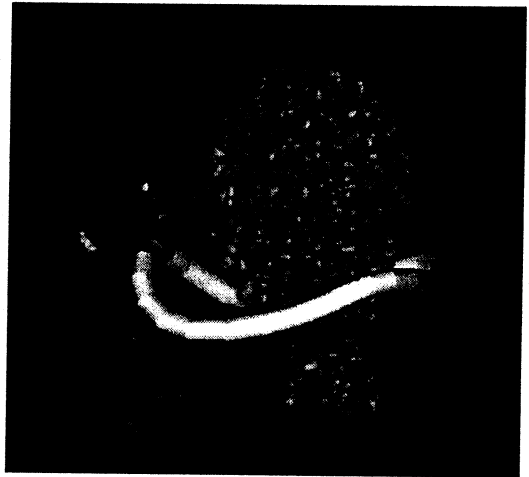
Hybrid visualisation of annulus surface model combined with colour Doppler signal.
